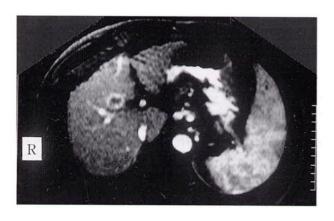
Dynamic MRI shows hypointense mass with a dense ring enhancement in the early phase after bolus injection of 0.05 mmol//kg gadopentetate dimeglumine (Gd-DTPA) in the hilar region.
